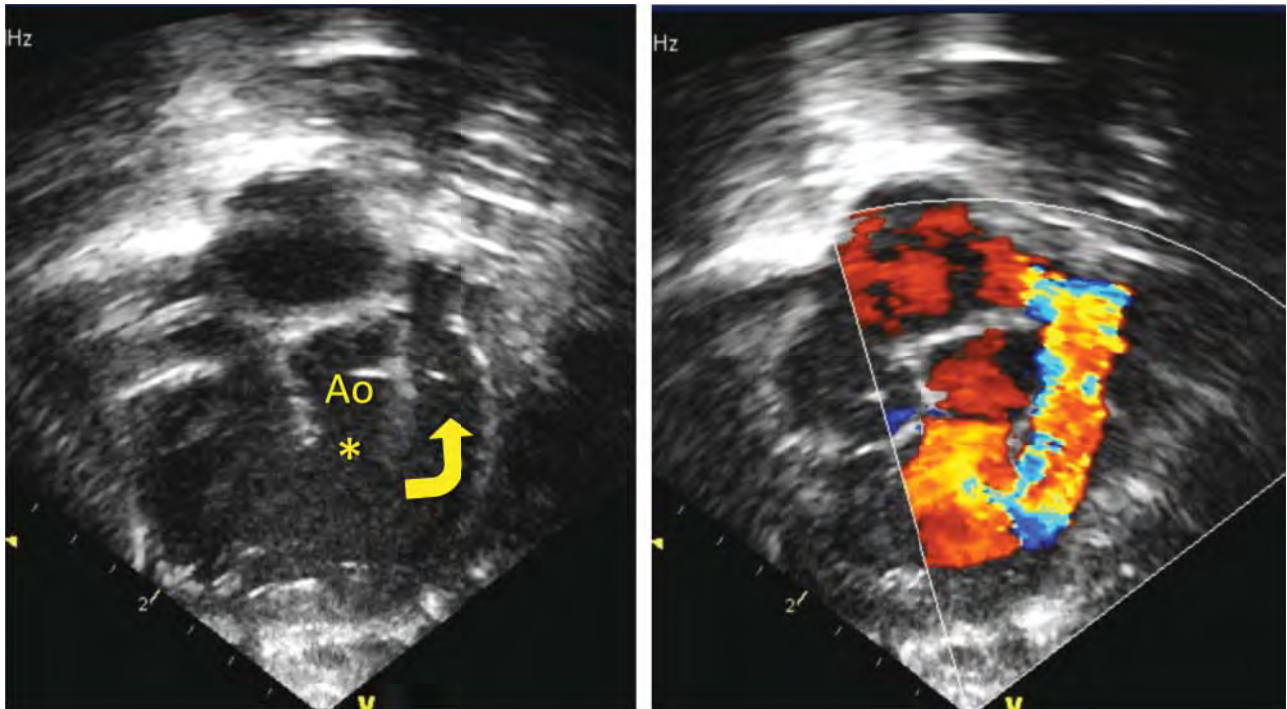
Subcostal right anterior oblique (right ventricular inflow–outflow) view showing ventricular septal defect (*) and infundibular stenosis (arrow) with aliasing of flow with color Doppler interrogation.
